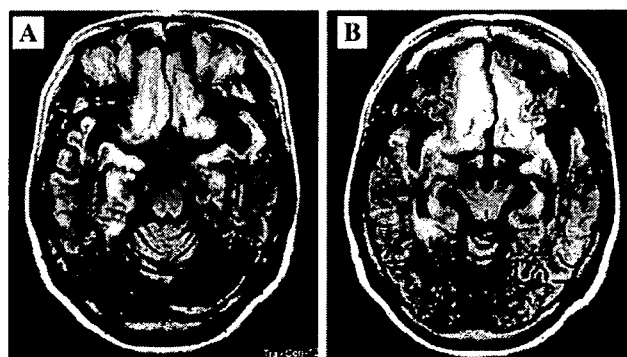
Follow-up MRI (recurrence at 10 months after the onset) findings. FLAIR images show improvement of the lesions in the bilateral temporal lobes (A), but there is expansion of hyperintense areas in the bilateral frontobasal lobes. (B).
